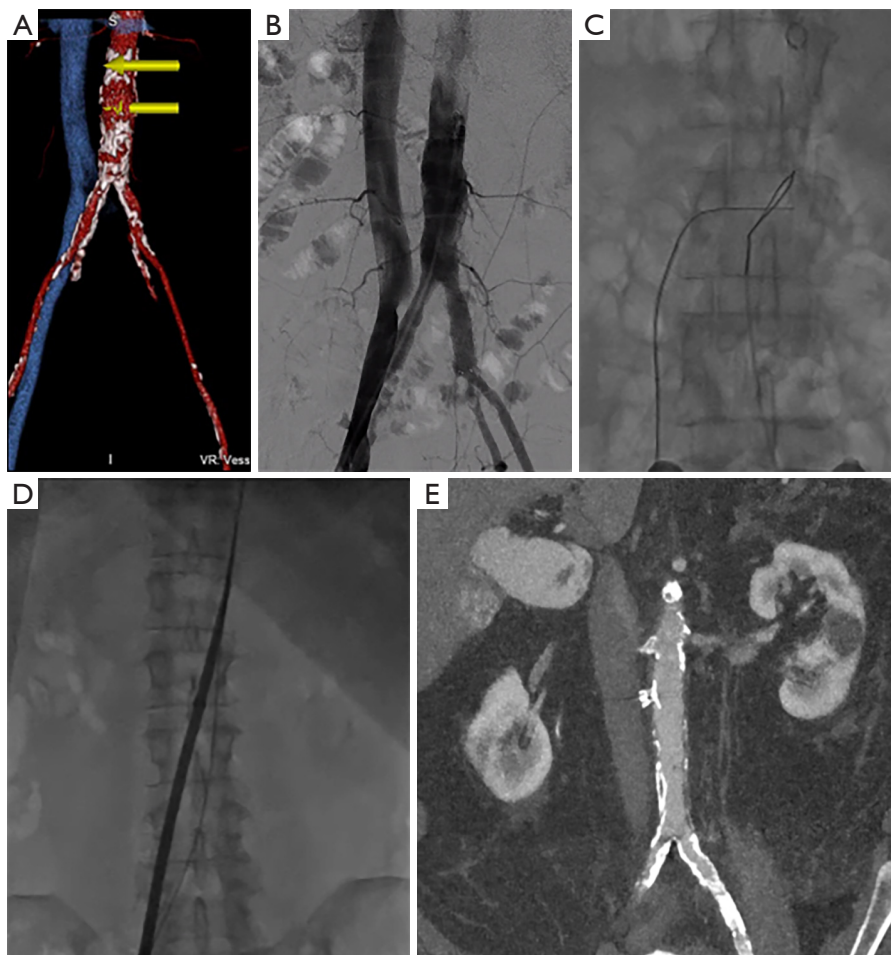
Standard steps for transcaval TAVR procedure. (A) CT plan with yellow arrows showing suitable crossing target; (B) Aortogram/cavagram; (C) electrified wire crossing into aortic snare; (D) TAVR delivery sheath from femoral vein into aorta; (E) final closure of aorto-caval tract with ADO-1 plug.
